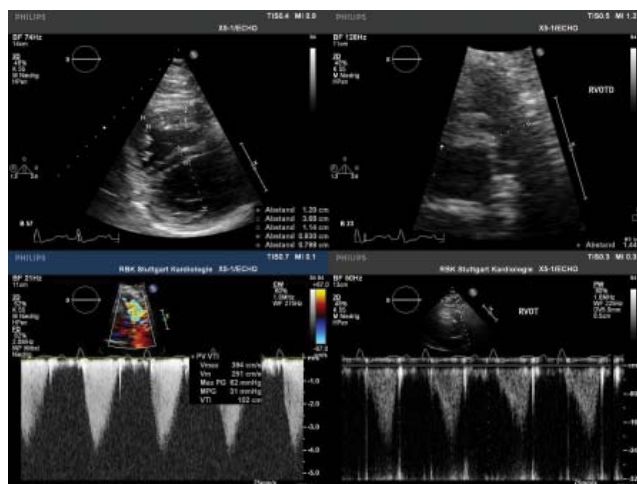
Transthoracic echocardiography. Upper-left: parasternal short axis view- hypertrophied RV with a D-shaped LV secondary to RV pressure overload; Upper-right: parasternal short axis view-narrowed RVOT; Lower-left: short axis view, Continuous Wave Doppler- transpulmonary valve gradient of 62mmHg; Lower-right: short axis view, Pulsed Wave Doppler- RVOT (subvalvular) gradient of 16mmHg.
